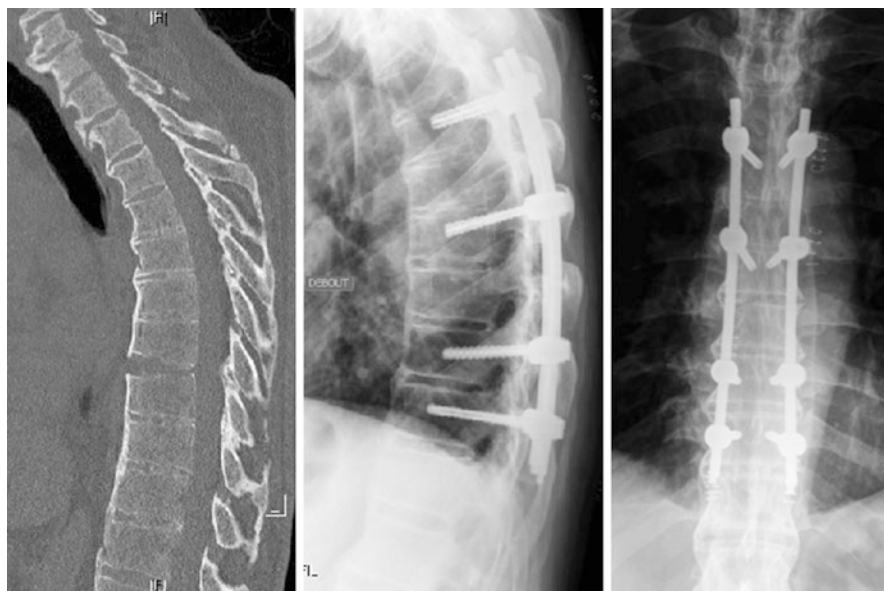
Preoperative CT and postoperative radiographs of a patient with unstable thoracic fracture treated by minimal invasive percutaneous instrumentation
